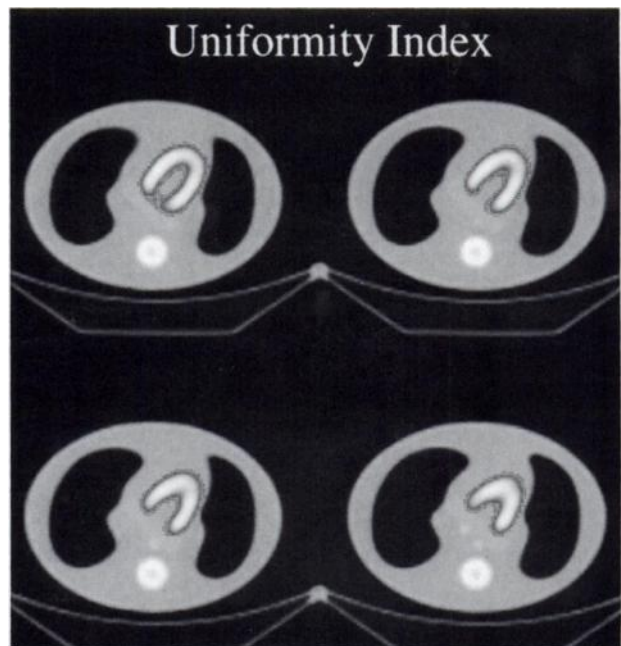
Transverse slices of SPECT images, registered using uniformity index, overlaid on CT images.
